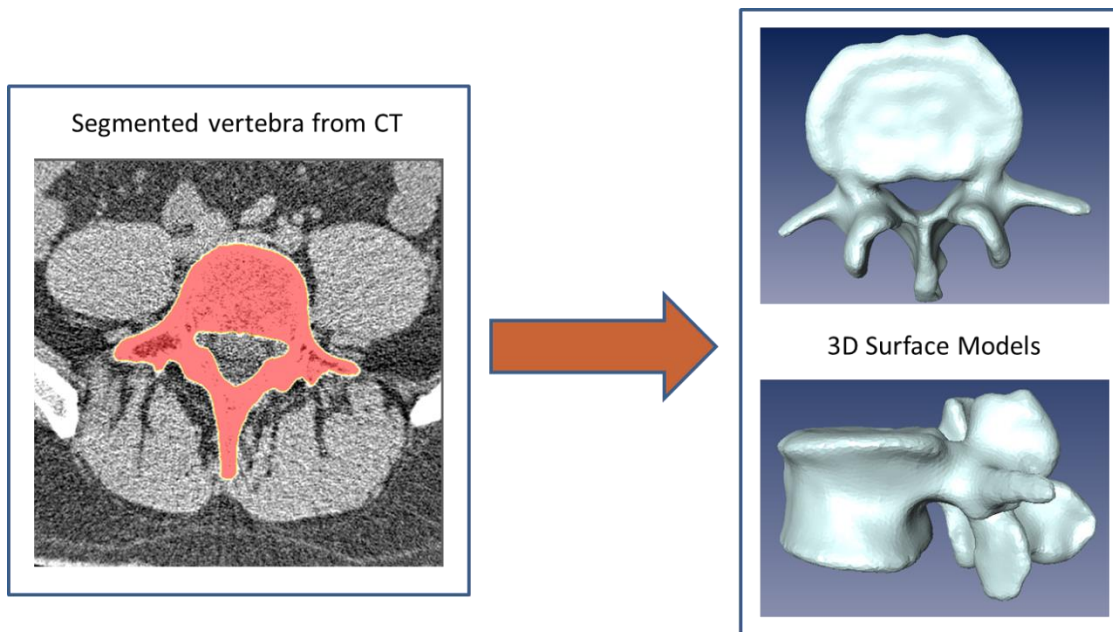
Boundaries of the bones are segmented in slices of a CT scan. Adjacent segmentations are joined together to generate 3D model of the vertebrae.
